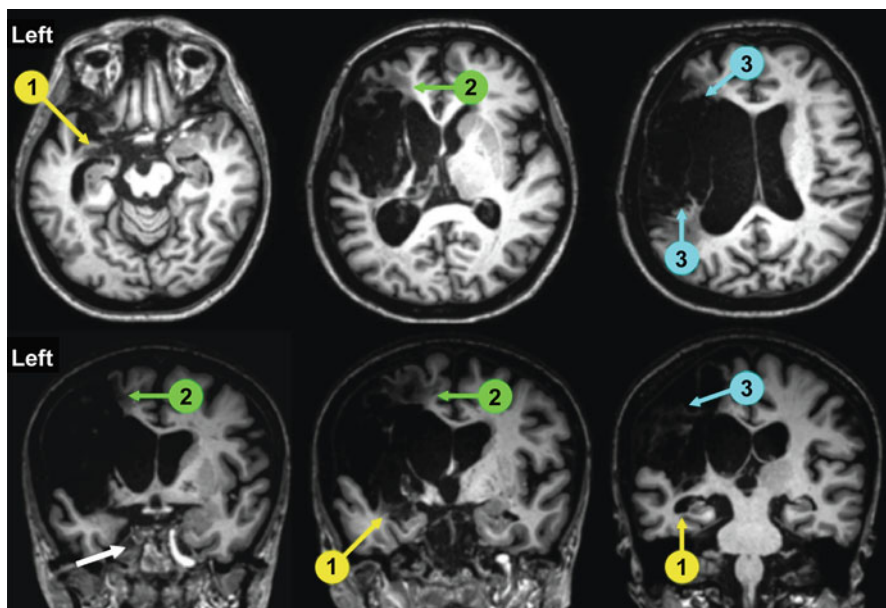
Structural MRI of a patient with long-lasting (3 years) nonfluent aphasia (spontaneous speech limited to single words and perseverations) showing a large infarction in the left middle cerebral artery territory. Axial and coronal 3T MRI slices show the full extension of the lesion involving the fronto-temporoparietal cortex and extending deeply to insula, basal ganglia, and white matter tracts. Despite intensive aphasia therapy and a trial of memantine (20 mg/day during 3 months), no changes were noted in oral productive functions. Involvement of brain structures critical for recovery such as the hippocampus (1, yellow circles and arrows), subcallosum fasciculus (2, green circles and arrows), and arcuate fasciculus (2, blue circles and arrows) most likely accounted for the lack of recovery of verbal output
